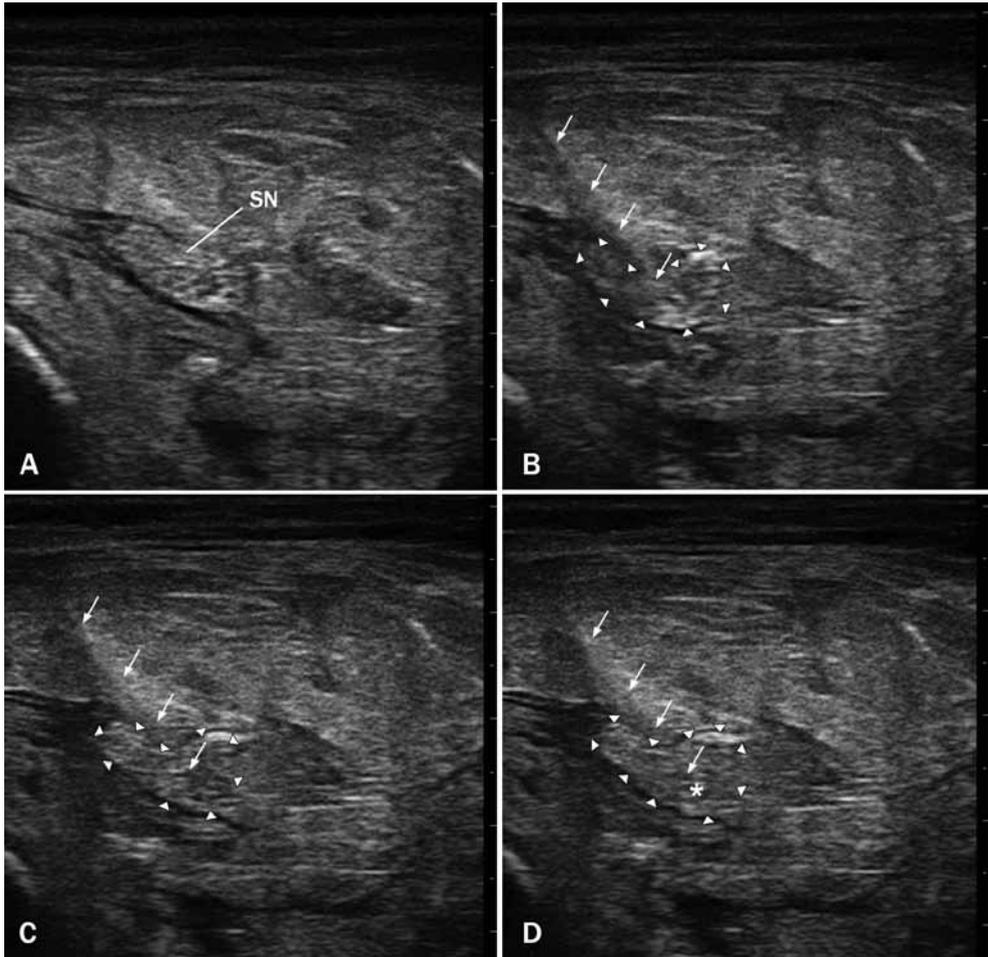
Ultrasound overview of the sciatic nerve, SN (A), insertion of needle and indentation of the nerve wall (B), needle tip inside the nerve adjacent to the nerve fascicles (C), and increase in nerve surface area in combination with change in echogenicity after injection of 0.5 ml of injectate (D). Arrowheads show the surroundings of the sciatic nerve, arrows point to the needle track. Asterisk shows immediate change in internal echogenicity.
